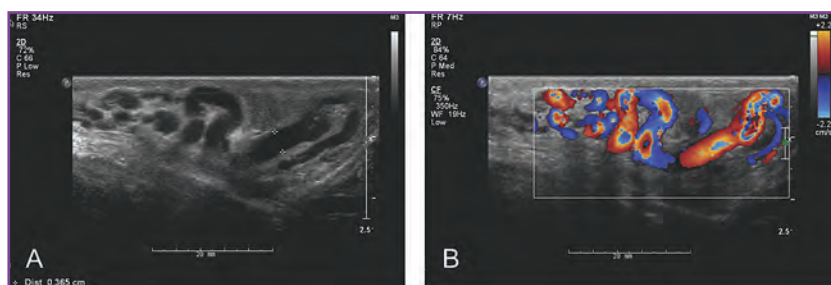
Ultrasonographic images of a left grade 3 varicocele without Doppler imaging (A) and with Doppler imaging (B).
